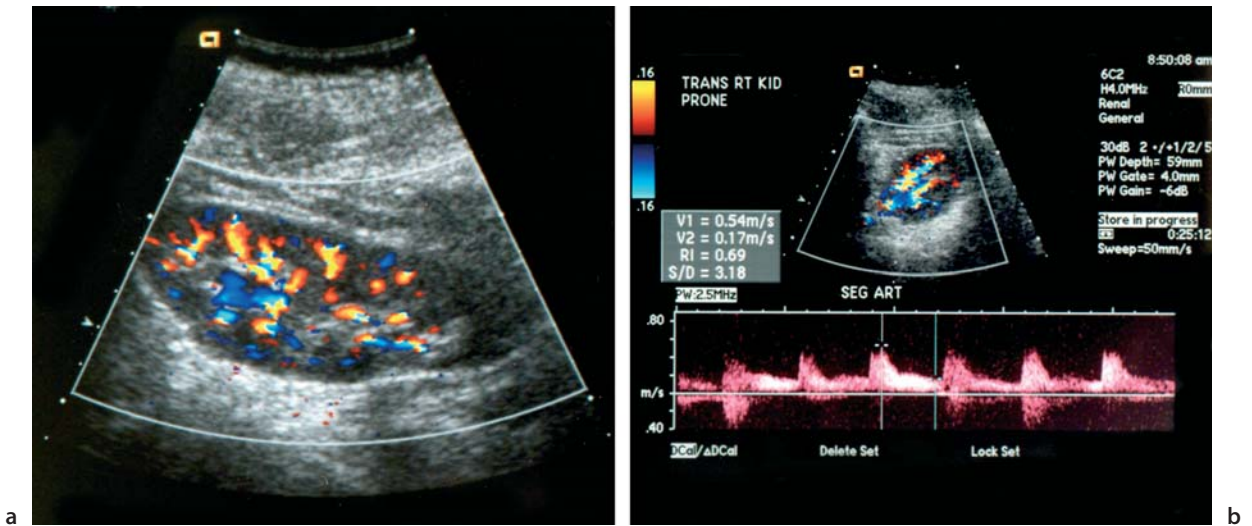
Doppler ultrasound
